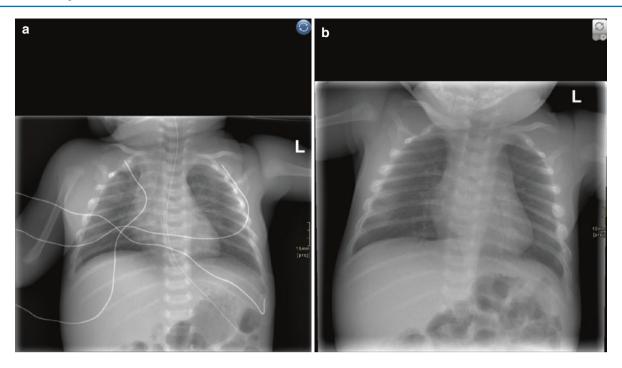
(a) Chest radiograph showing bilateral pleural thickening and an acute rib fracture on the left side. (b) Follow-up radiograph shows bilateral healing rib fractures
